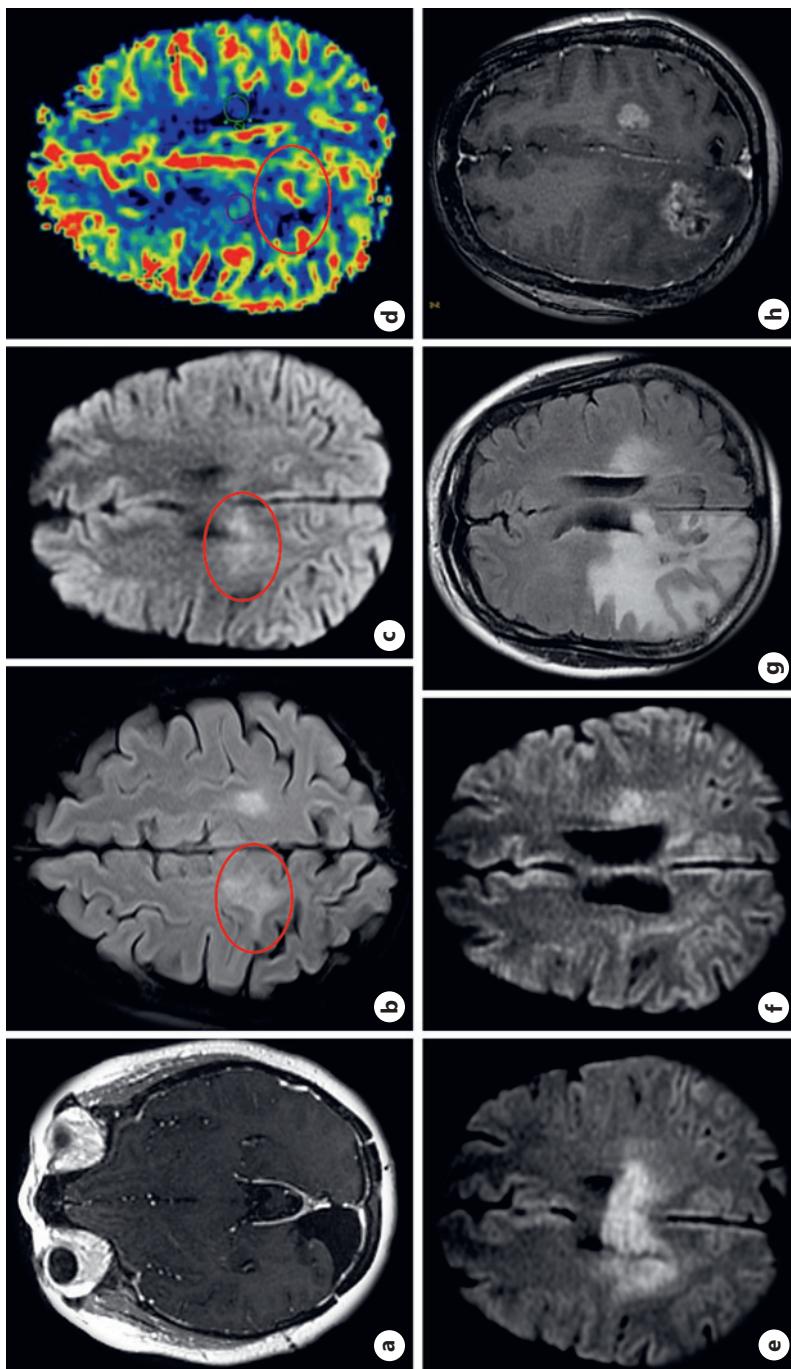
a Immediate postoperative imaging shows no residual tumor. 2020: a new area of increased FLAIR signal (b) and restricted diffusion (c) in the white matter of the right corona radiata and centrum semiovale, with increased perfusion (d) as per DSC technique 2021: new markedly restricted lesions in the body of the corpus callosum (e) and left corona radiata (f). 2022: new progression to both cerebral hemispheres (g) with heterogeneous contrast enhancement (h). FLAIR, fluid-attenuated inversion recovery; DSC, dynamic susceptibility contrast.
